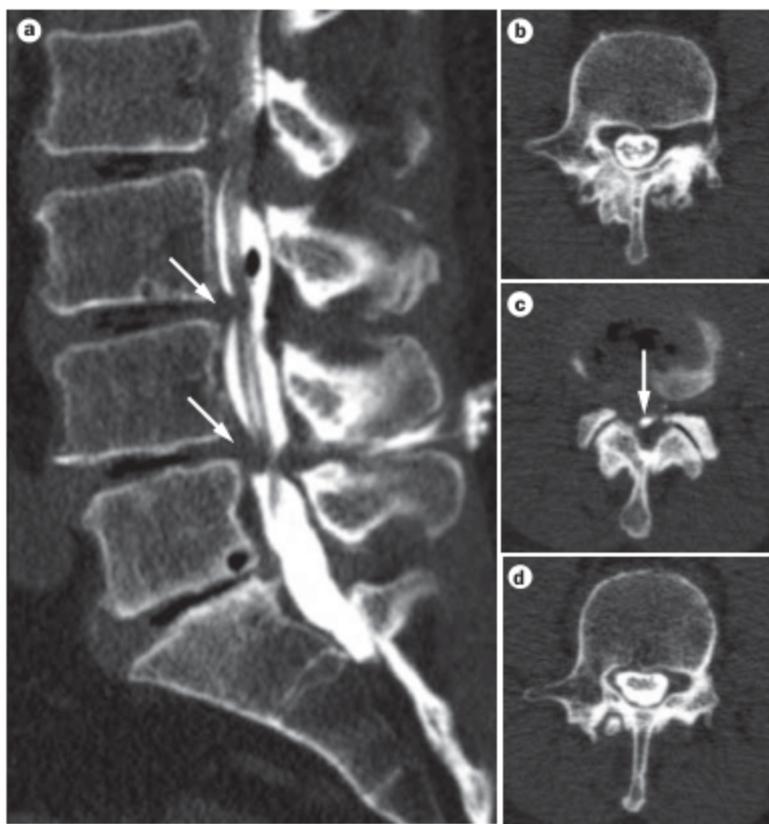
Multisegmental disc degeneration revealed by CT myelography. a | A sagittal reformatted CT myelograph reveals a multisegmental severe disc degeneration, with disc space height reduction, vacuum phenomenon and end-plate sclerosis of the lower lumbar spine, as well as thecal sac compressions at the L3–4 and L4–5 levels (arrows). b–d | Axial reformatted images show a circumscribed severe LSS of L3–4, with a typical hourglass constriction of the thecal sac (arrow) adjacent to relatively normal areas. Abbreviation: LSS, lumbar spinal stenosis.
